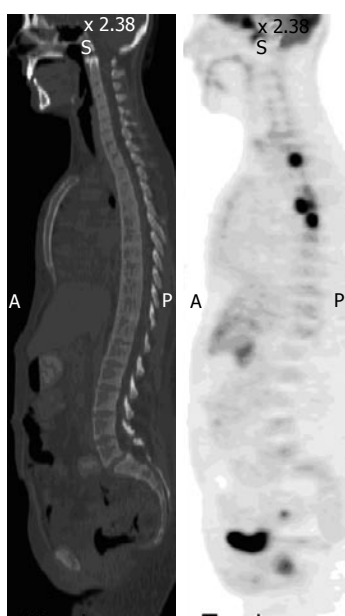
Lymphomatous disease of bone. A 28-year-old man with disseminated B-cell lymphoma had fluorodeoxyglucose positron emission tomography-computer tomography (PET-CT) for initial staging. Sagittal PET image shows foci of intense uptake in the vertebral bodies of the upper thoracic spine, but the CT is unremarkable in the corresponding sites. Repeated scan 3 mo after chemotherapy demonstrate resolution of uptake in the bones as well as lungs and lymph nodes.
